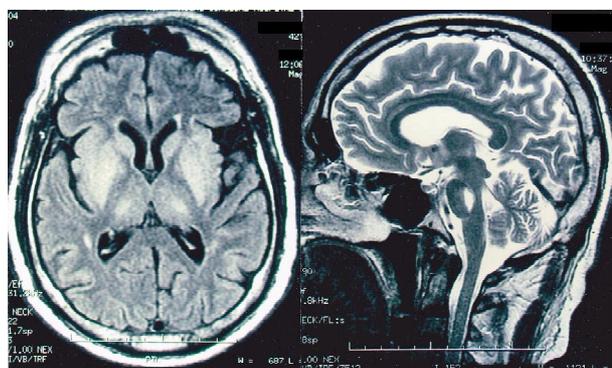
Axial FLAIR and sagittal T₂-weighted MR images of the brain showing symmetrical hyperintense lesions in the basal ganglia, thalami and base of the pons in the acute stage.
